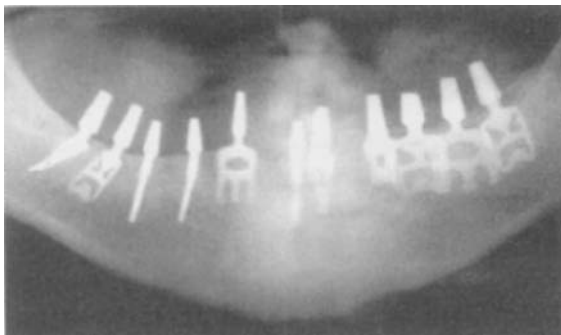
■ Radiograph showing bucco/labio-lingual, mesio-distal, and oblique placement of combination root form and plate/blade form implants according to variation in ridge width along the arch to achieve maximum cortical contact.
